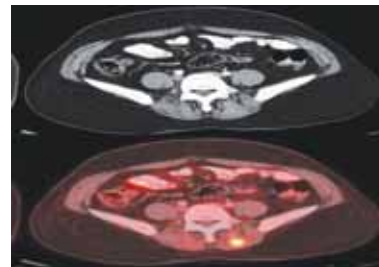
PET-CT (lower two images) show unsuspected metastatic lesions with corresponding CT images (upper two images).
